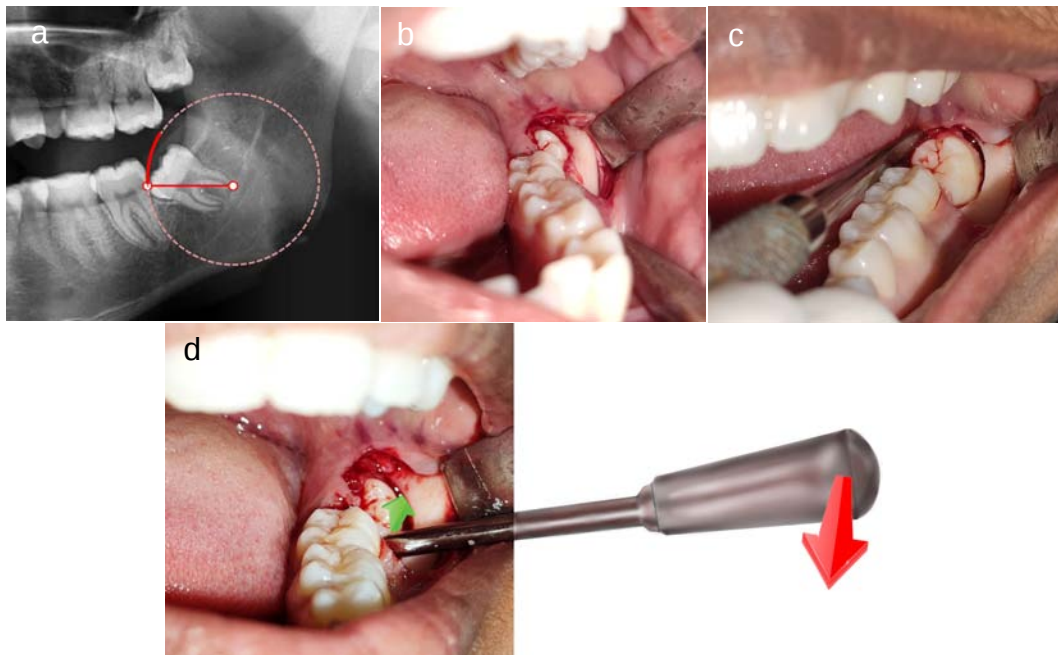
An orthopantomogram shows a mesioangular impaction of the lower right third molar. The distal root apex and mesial cusp tip of the impacted tooth are joined together to form the radius, shown by the red line. The exclusion of the adjacent second molar from the rotation's arc makes tooth sectioning unnecessary (a). The left lower third molar demonstrates interaction of the second molar with the arc of rotation. This indicates that the impacted tooth requires sectioning (b).
